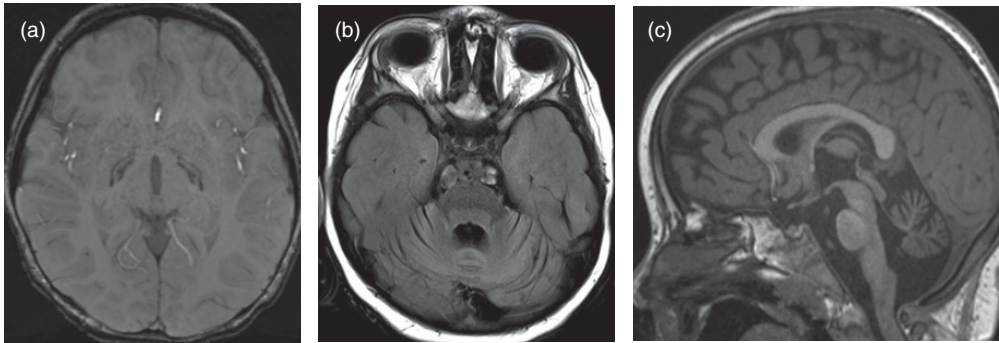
Suspected infantile neuroaxonal dystrophy, presenting as hypotonia and developmental regression at 14 months of age. (a) Axial SWI at the level of the basal ganglia demonstrates an unusual degree of susceptibility in the globus pallidus for a patient of 4 years. (b) Axial FLAIR and (c) sagittal T1 images demonstrate atrophy of the cerebellum with associated folia FLAIR hyperintensity.
